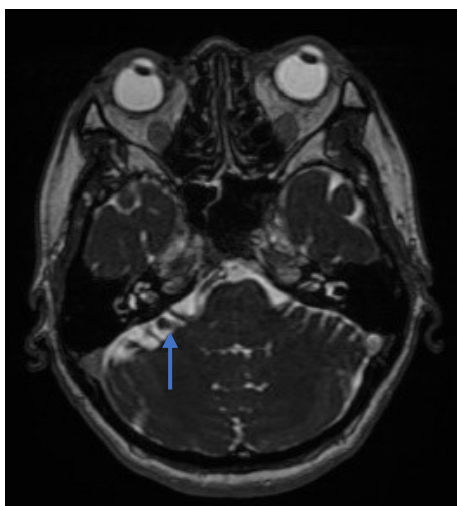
Neurovascular attachment (arrow) on brain MRI (FIESTA).
